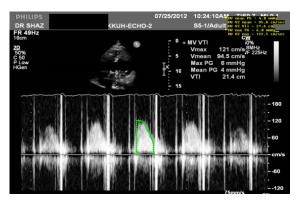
Shows the Doppler reduced mean diastolic gradient 24 hours after treatment started.
